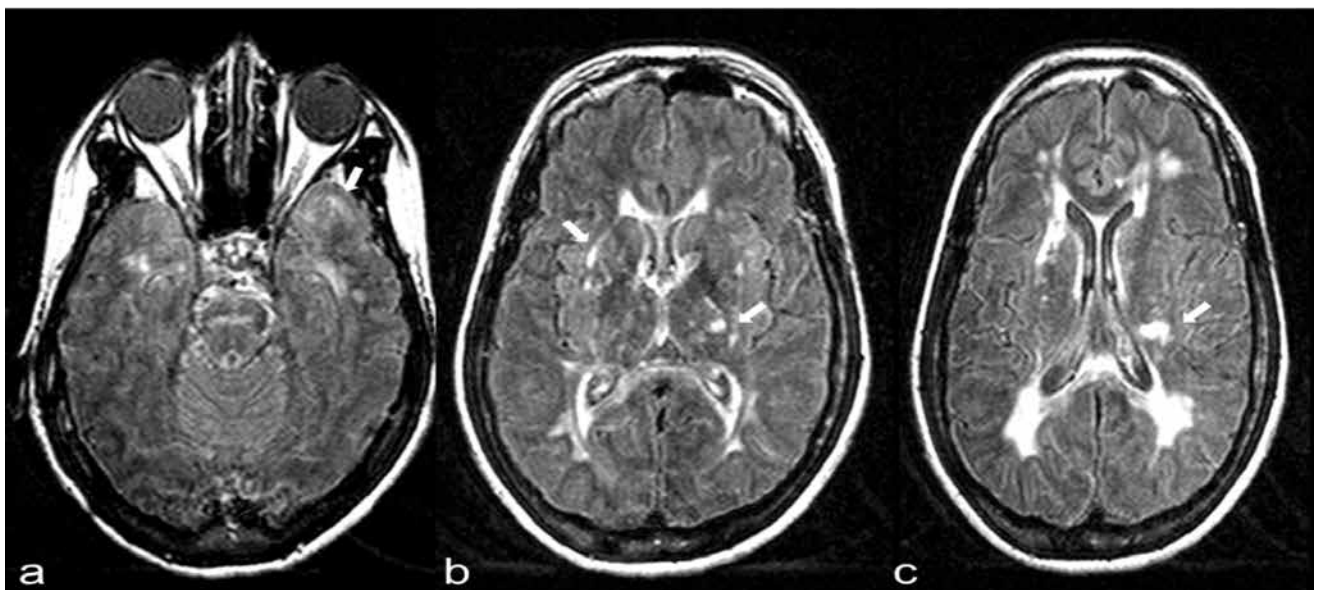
(a-c) Brain magnetic resonance imaging reveals high-signal-intensity lesions (arrows) with lacunar lesions in the anterior temporal lobe, both periventricular and subcortical white matter, corpus callosum, thalamus, and basal ganglia on axial FLAIR, concomitant with mild deep cerebral white matter atrophy. FLAIR: fluid attenuated inversion recovery.
